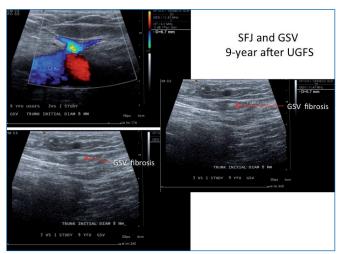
Nine years follow-up after ultrasound-guided foam sclerotherapy. GSV, great saphenous vein; CFV, common femoral vein; SFJ, saphenofemoral junction. (Courtesy C. Hamel-Denos MD)
